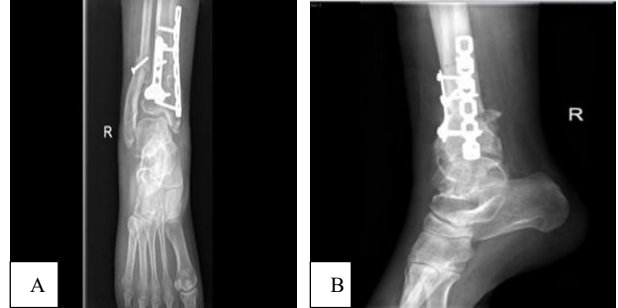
(A and B): Radiograph in 6 weeks follow-up after supramalleolar osteotomy.
